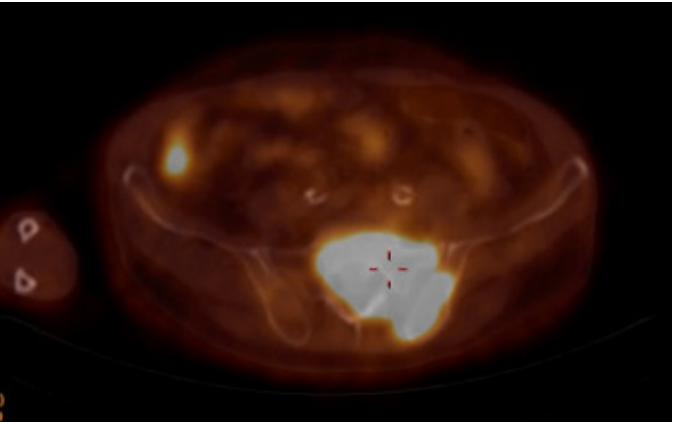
Baseline 18F-FDG PET-CT: extensive hypermetabolic lesion involving most of the left sacral ala and left iliac wing (SUVmax 14.1).
